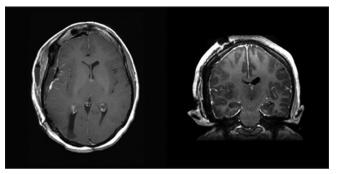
Post-operative MR images showing complete resection of the tumor and the absence of hyper intense lesions near the site of tumor excision on axial gadolinium enhanced TI-weighted axial (Left), and coronal images (Right)
